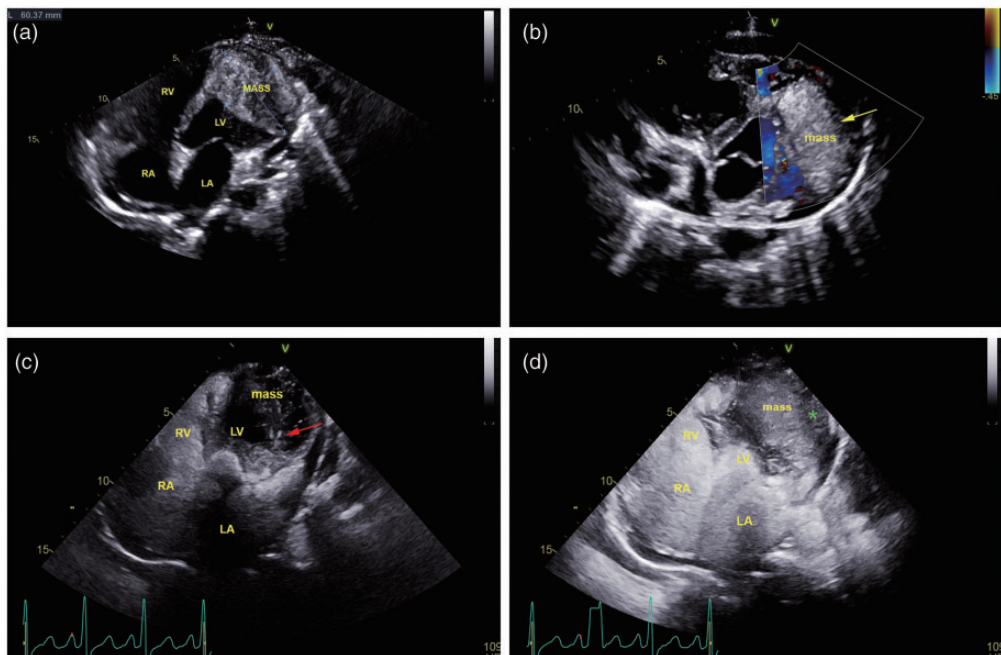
(a) Transthoracic echocardiographic four-chamber view showing a mass in the inferolateral wall of the left ventricle. (b) Echocardiographic four-chamber view with color Doppler flow imaging showing no flow signals within the mass (yellow arrow). (c) Myocardial contrast echocardiography showing that the contrast agent entered the tumor (red arrow). (d) The contrast enhancement of the mass is higher than that of the normal myocardium (green asterisk).
